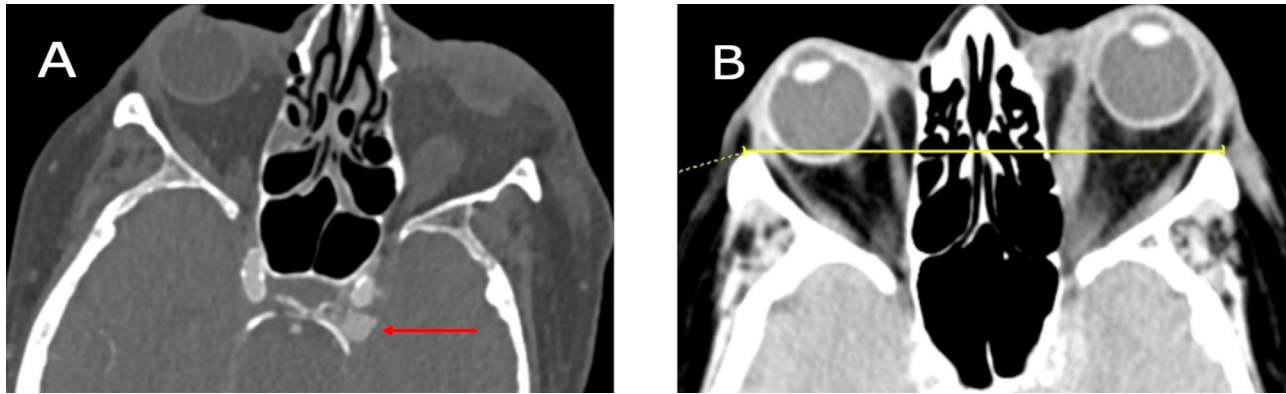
(– A) Axial head CTA demonstrates early filling of the posterior left cavernous sinus, which is suspicious for a CCF. (B) Axial NCCT demonstrates left sided proptosis as indicated by significant anterior displacement of the left globe compared to the right.
